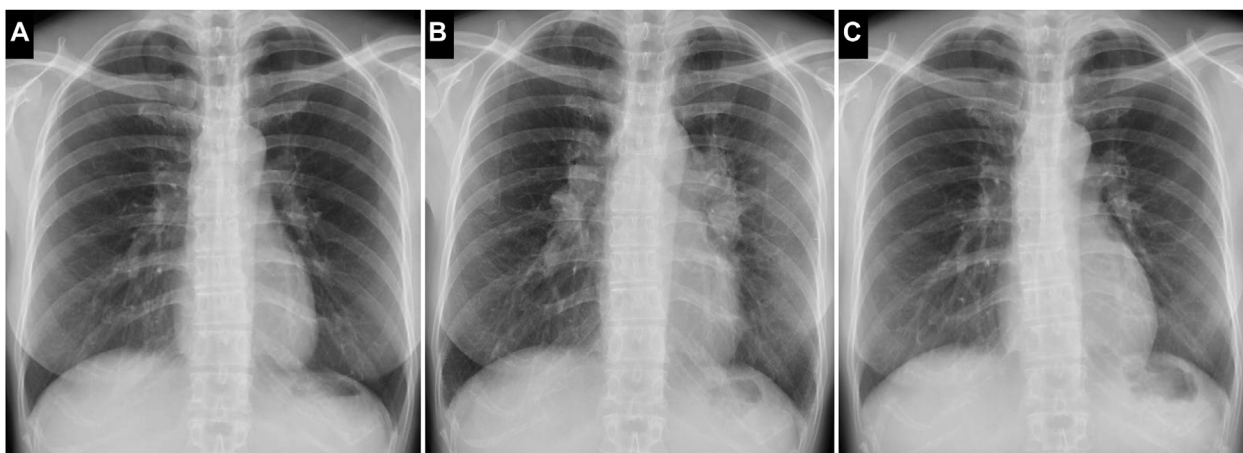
Chest radiograph throughout the time series. A, No significant lung lesions were observed before postoperative hormonal therapy and radiation therapy. B, Bilateral hilar lymphadenopathy was observed in a chest radiograph taken just after the skin biopsy. C, Bilateral hilar lymphadenopathy was gradually reduced after the discontinuation of postoperative therapy.
